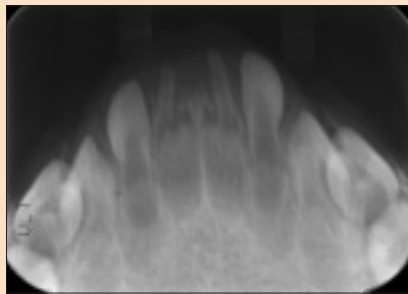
Mandibular anterior occlusal radiograph taken at approximately age 9.5 months. Radiopaque tissue has formed in the areas where tooth 71 exfoliated and tooth 81 was extracted.
